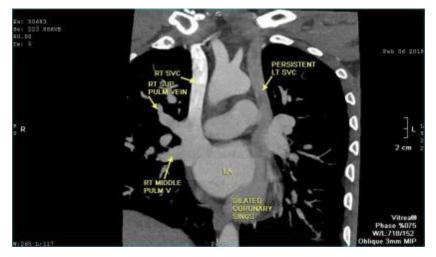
multi-slice CT, showing the site of LSVC in relation to main PA and left PA.
